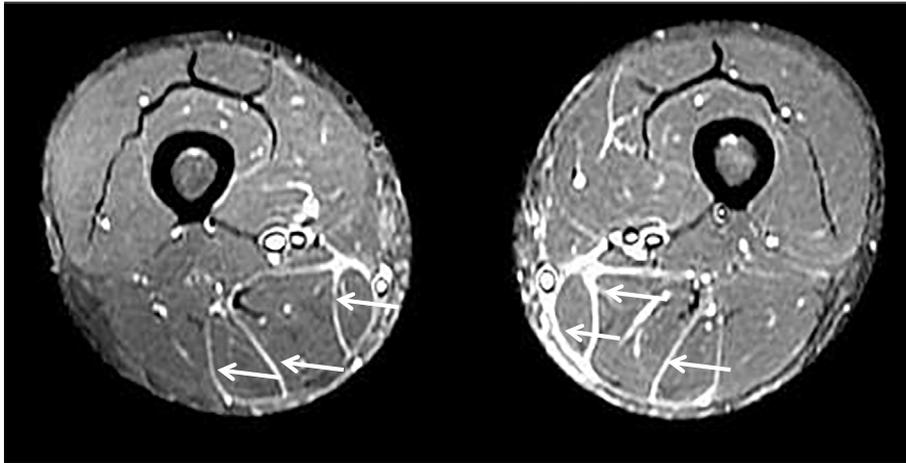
Plain STIR MRI of the muscle in the thigh. The arrows indicate sites of thickening of the fascia.
